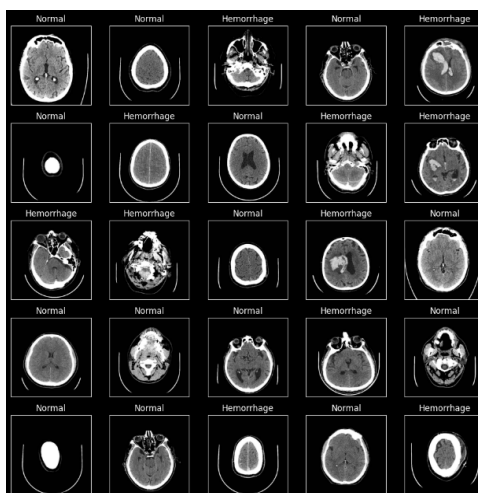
Normal and Hemorrhage Brain MRI
